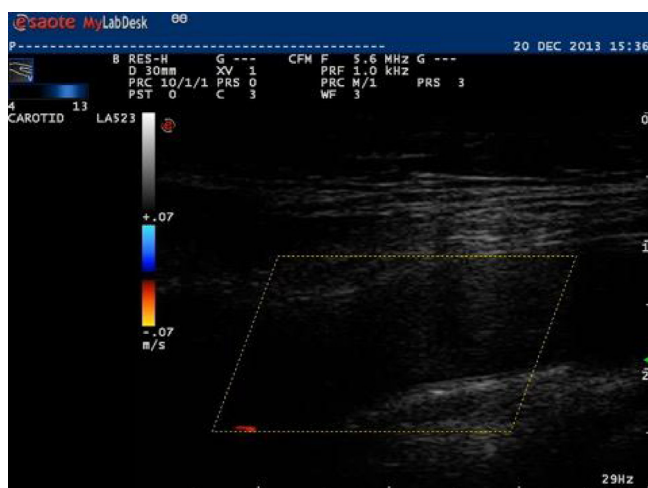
Color duplex ultrasound of carotid arteries. Case 1. Thrombus in the proximal RICA causing occlusion. Device – EsaoteMyLab60.
